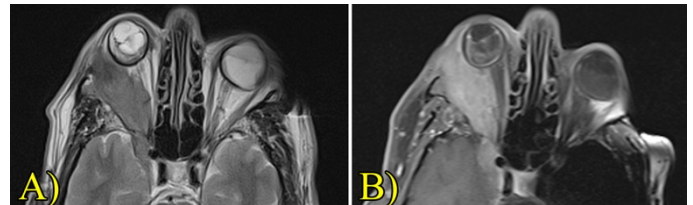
T2 sequence MRI (A), showing right-sided orbital mass extending to the Meckel's cave through the orbital canal. The tumor showed contrast enhancement on the T1 contrast-enhanced sequence (B)
